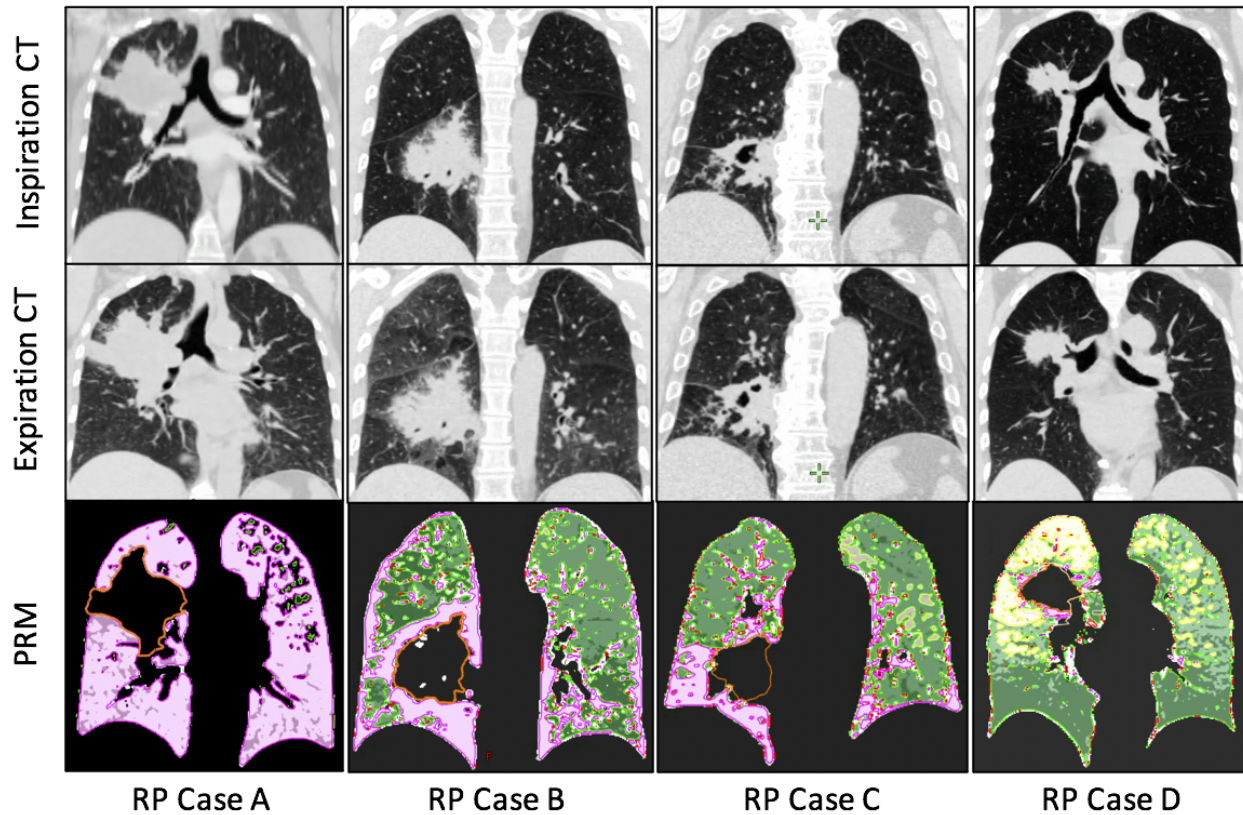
Single slice images for the inspiration (top row) and expiration (middle row) CT scans and PRM classification distributions (bottom row) showing normal parenchyma (green), small airways disease (yellow), and parenchymal disease (purple) in the four lung cancer patients that incurred Grade 2 RP.
